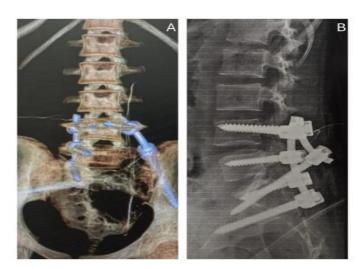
Post-operative CT 3D reconstruction image shows screw in PA view with lumbo-pelvic fixation, Figure 4B- X-ray lateral view with lumbo-pelvic fixation
